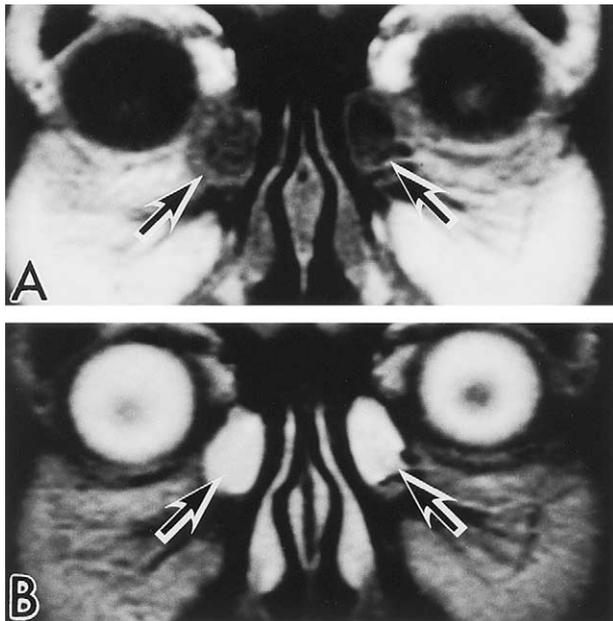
Magnetic resonance imaging coronal sections of a patient (case 8) treated by standard external dacryocystorhinostomy (A) T₁-weighted image shows both intralacrimal sac spaces to be homogeneously hypointense with respect to the lacrimal sac walls (arrows). (B) T₂-weighted image shows the lacrimal sac interiors to be homogeneously hyperintense (arrows).
